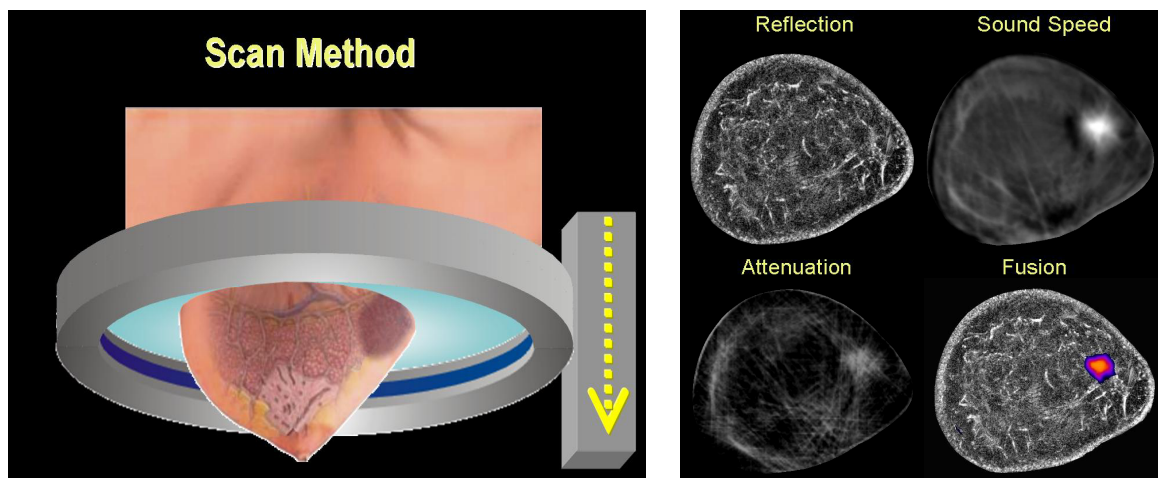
The ultrasound ring array (grey) surrounds the breast as it moves on a vertical trajectory from the chest wall to the nipple, acquiring data at discrete steps along the way. Each such dataset yields cross-sectional coronal images of reflectivity, sound speed and attenuation, as shown. Since the images are constructed from the same data, they are intrinsically registered, allowing fast and accurate image fusion, as shown.
